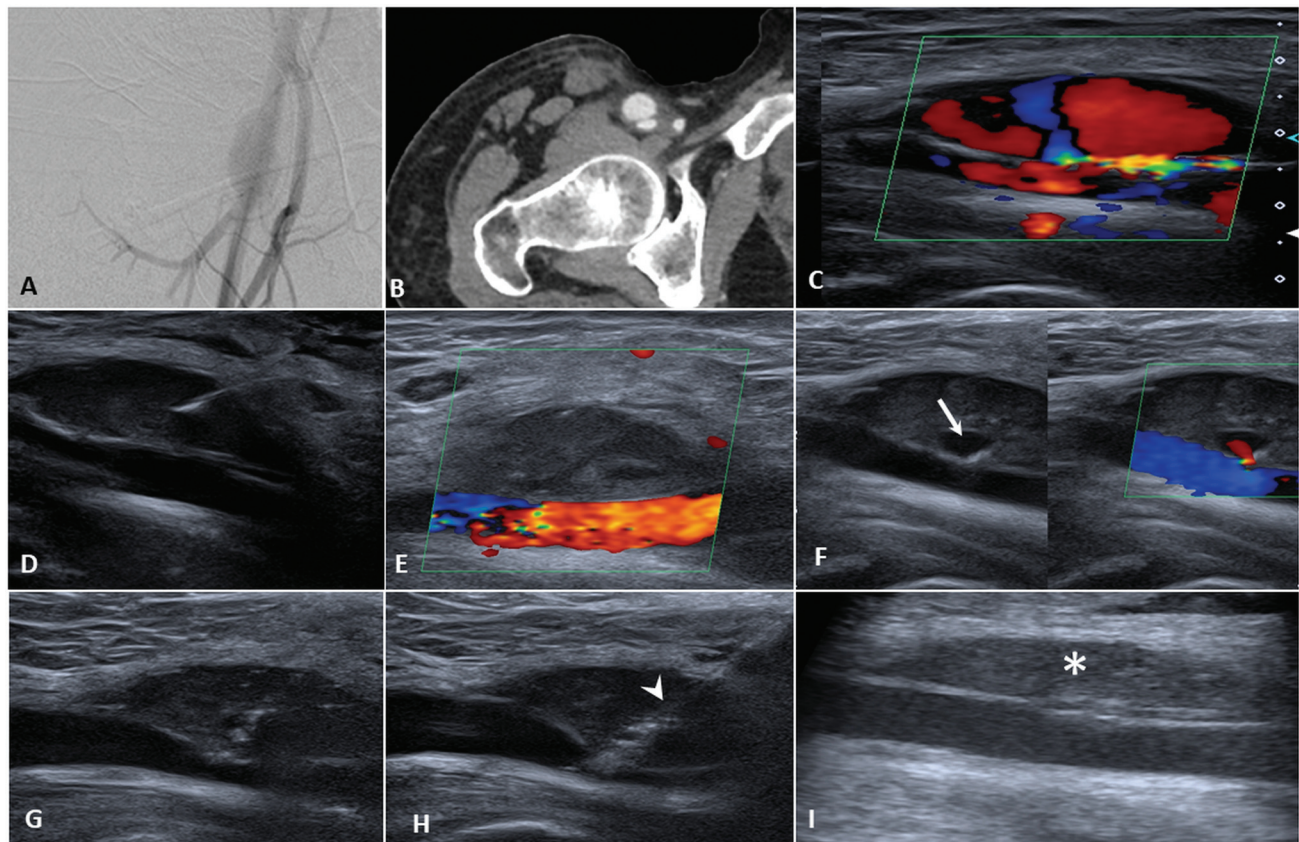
Digital subtraction angiography (A), computed tomography (CT) angiography (B), and color Doppler (C) image shows a dissecting pseudoaneurysm (PSA) arising from the superficial femoral artery (SFA). Thrombin injection done after balloon occlusion of the SFA (D), which shows complete thrombosis of the PSA (E). However, ultrasound and color Doppler done on the next day shows recanalization of the PSA with a small sac (white arrow in F). Transaneurysmal suturing of the neck done (G and H). Micropuncture needle (arrowhead in G) and closure device (arrowhead in H) is seen through the PSA into the SFA. Complete thrombosis of the PSA seen subsequent to the suturing (asterisk in I).
